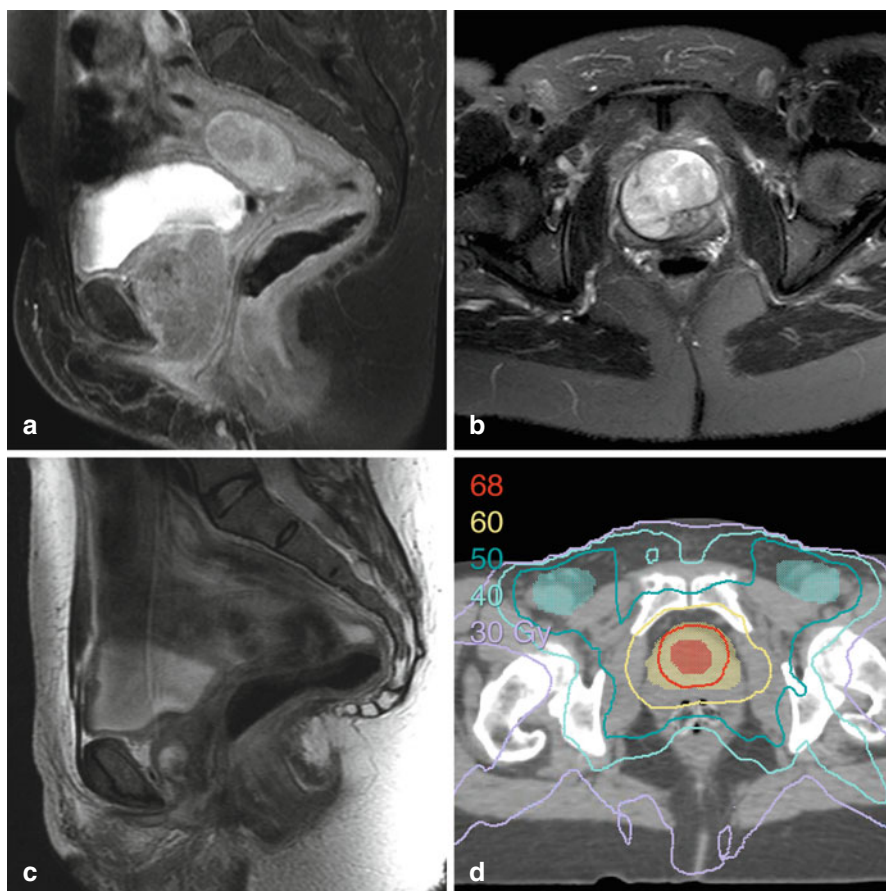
A large T3N0M0 clear cell carcinoma of the urethra in a 60-year-old African-American woman with a past history of a resected urethral diverticulum. The patient presented with acute urinary retention after a several-month history of a weak urine stream. MRI (a) showed a 4.5 × 6 cm urethral mass that abutted but did not infiltrate the vaginal wall. She initially received neoadjuvant chemotherapy with cisplatin, paclitaxel, and methotrexate; this was changed to methotrexate, vinblastine, doxorubicin, and cisplatin because of paclitaxel-related neuropathy. After 14 weeks of chemotherapy, her MRI demonstrated an excellent partial response (c) and she was referred for radiation therapy. The primary site and inguinal and iliac lymph nodes were treated using intensity-modulated radiation therapy (IMRT) (d); she also received concurrent weekly cisplatin. At 4.5 years she has no evidence of disease and normal urinary function
